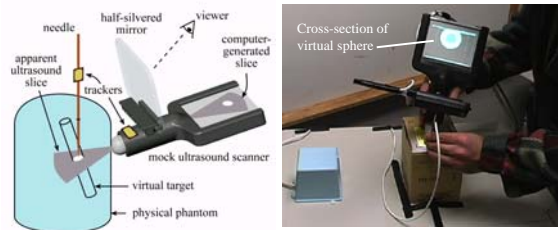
Original concept (left) and implementation (right) of virtual ultrasound
